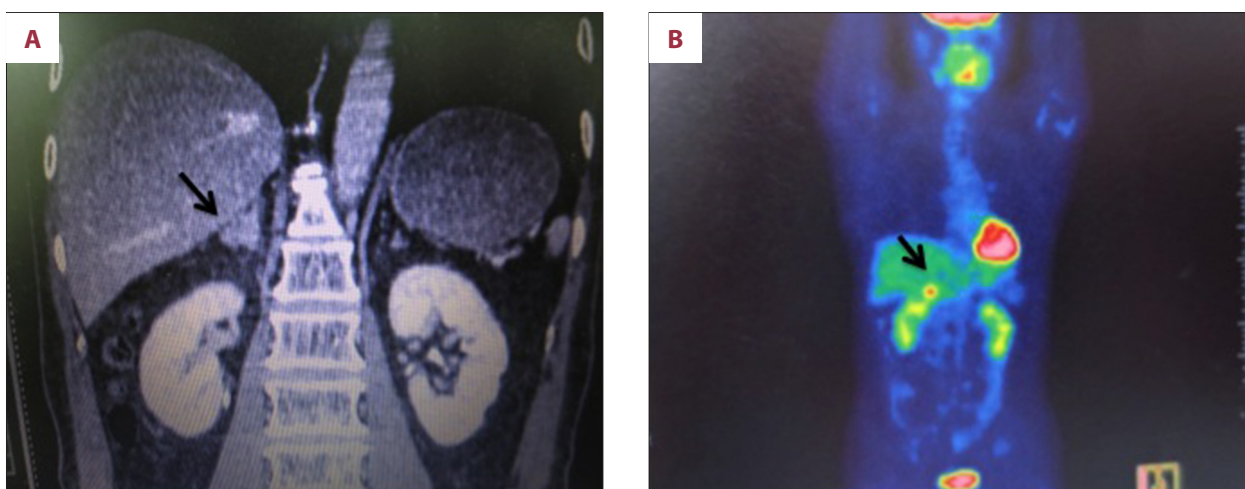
(A) Abdominal CT performed 3 years 8 months after the right upper lobectomy shows a right adrenal tumor (2.0×1.5 cm). (B) A PET/CT scan shows a moderate uptake in the tumor, with a maximum SUV of 6.7.
